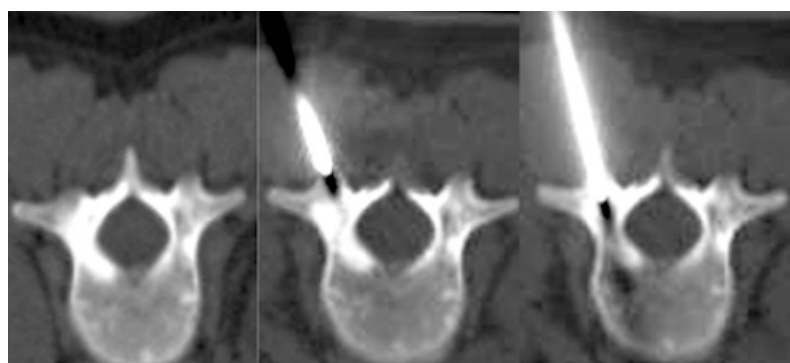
CT scan of the L4 lumbar vertebra demonstrating the CT-guided puncture biopsy steps.
